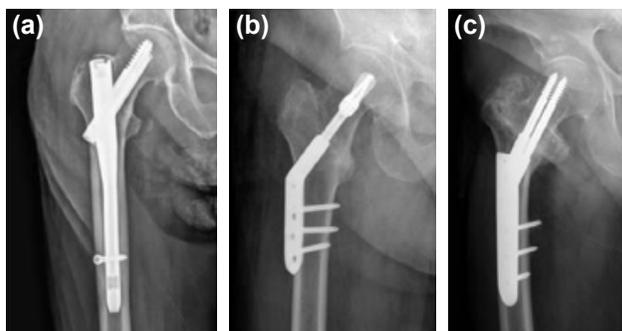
Final follow-up anteroposterior radiographic views of patients who had (a) PFNA, (b) DHS, and (c) PCCP.
